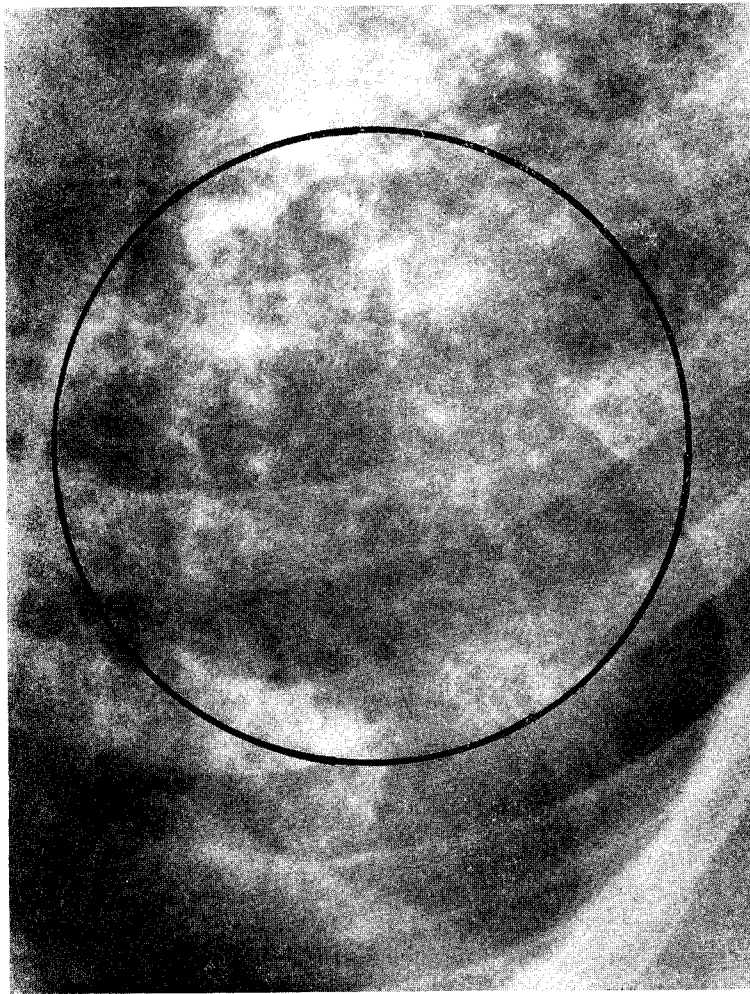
A 4 by 5 inch zonal reproduction from the same chest radiograph as Fig. 1. This demonstrates a circular 2.5 inch diameter aperture illuminated by the laser light in the center of the appropriate lung zone.
